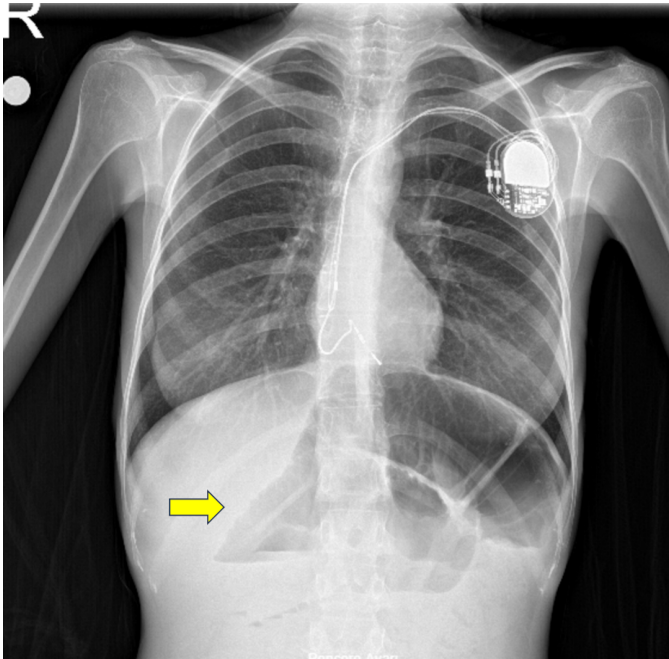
Air-fluid levels (arrow) in abdominal X-ray.
